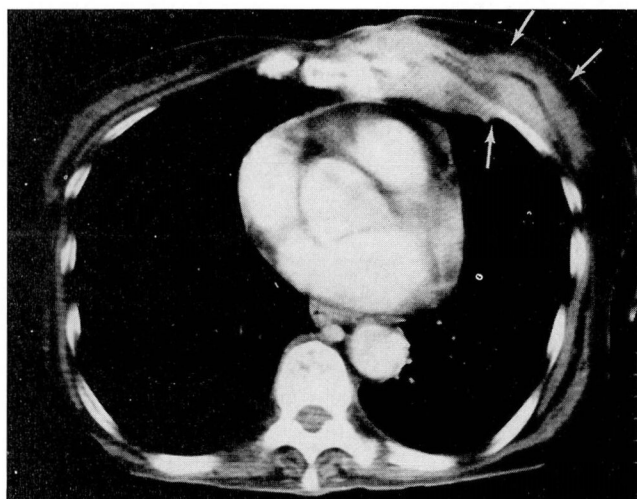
CT scan section of the chest depicting a soft tissue density over the left anterior chest wall with associated swelling of the breast. This process can be seen to extend to the pleural space (empyema necessitatis).
